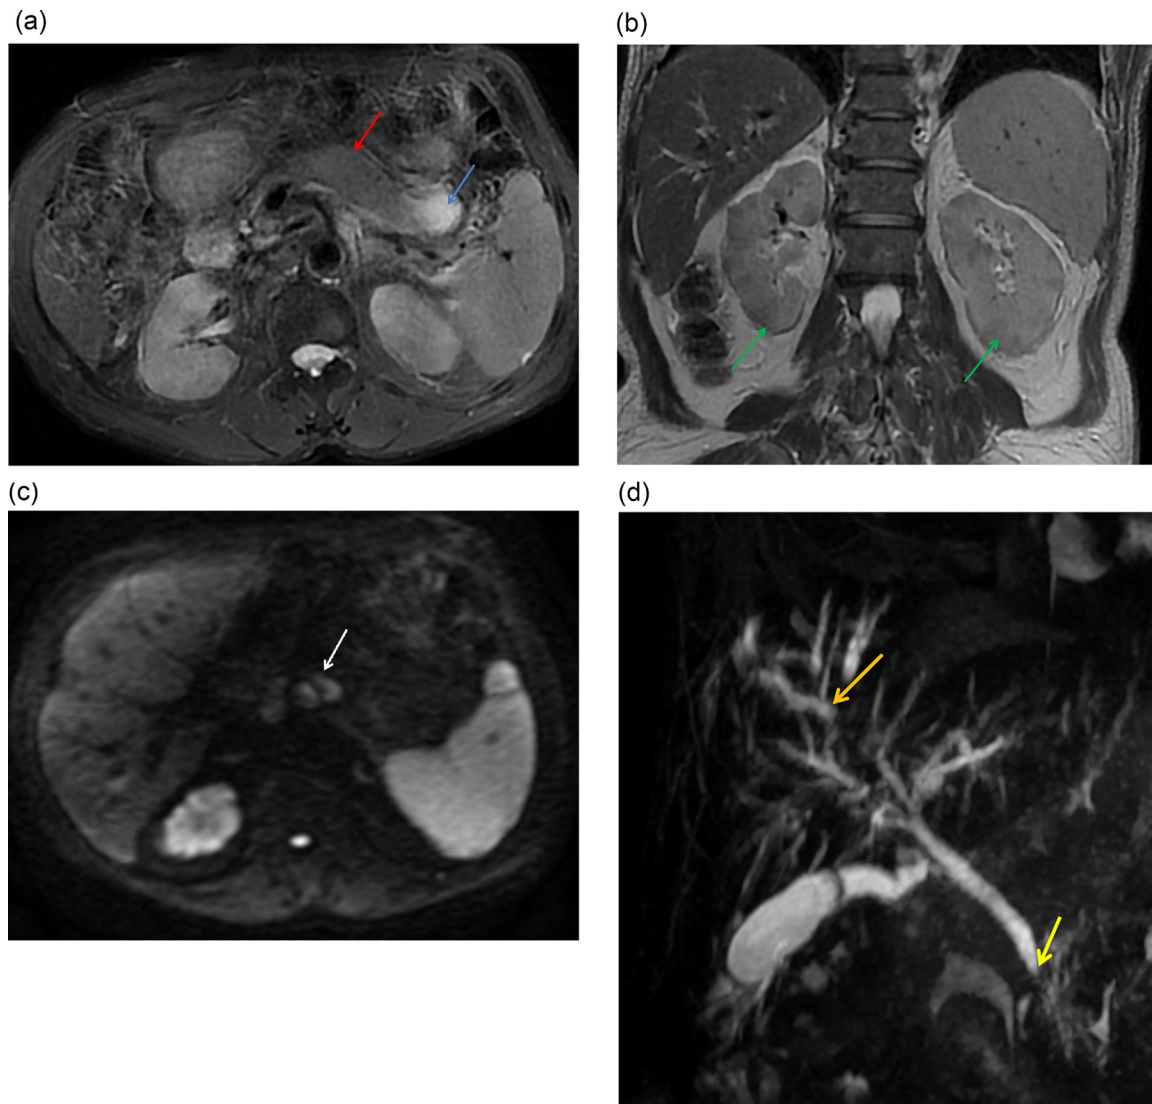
Magnetic resonance cholangiopancreatography: (A) Axial T2-weighted MR image shows enlargement of the pancreas with a "sausage-like" appearance (red arrow), and a thin-walled cyst in the tail, with homogeneous content (blue arrow). (B) Coronal T2-weighted MR image show hypointense peripheral renal lesions (green arrows). (C) Axial diffusion-weighted MR image ($b = 800 \text{ sec/mm}^2$) revealing peripancreatic lymphadenopathy (white arrows). (D) Coronal MR cholangiopancreatographic image shows several areas of stenosis and dilation of the right intrahepatic bile ducts (orange arrow), with filiform stenosis at the distal level of the main bile duct (yellow arrow).
